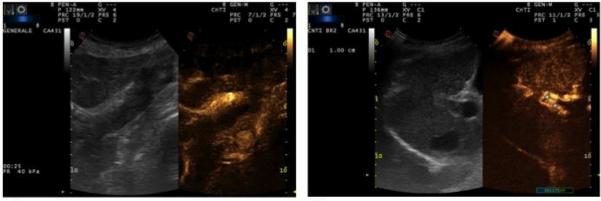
Contrast enhanced ultrasound shows intraluminal contrast signals during the portal venous phase confirming portal patency even when the portal vein flow is too slow for detection on conventional Doppler techniques. Arrows indicate the portal vein.
